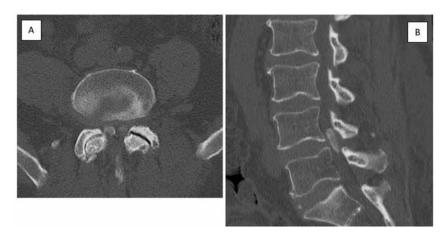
A. Axial CT scan showing the hyperdense lesion at the L4-L5 level with facet arthropathy (November 2020). B. Parasagittal CT scan demonstrating the hyperdense lesion (November 2020). CT, computed tomography.
